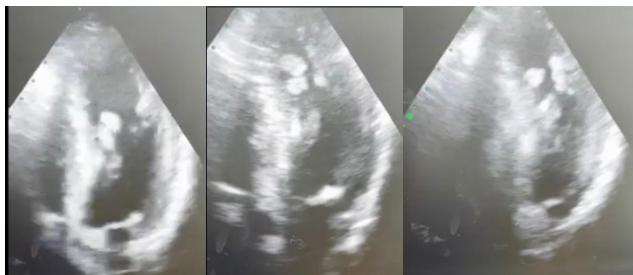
The first Echocardiography at the hospitalization
